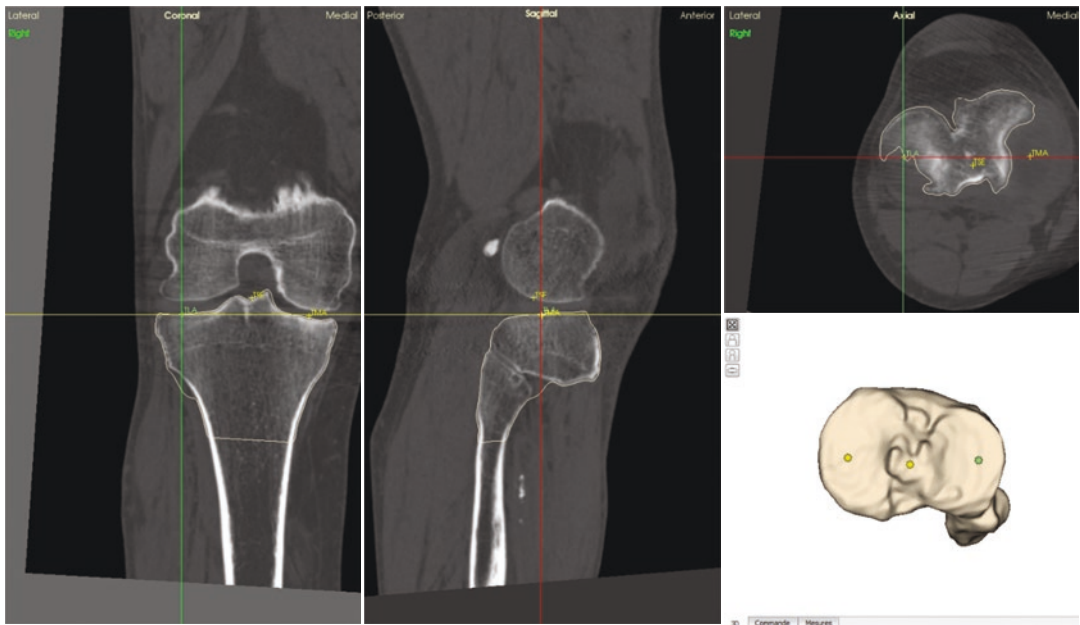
CT slices of a patient's knee and the lateral posterior condyle of the tibia selected
